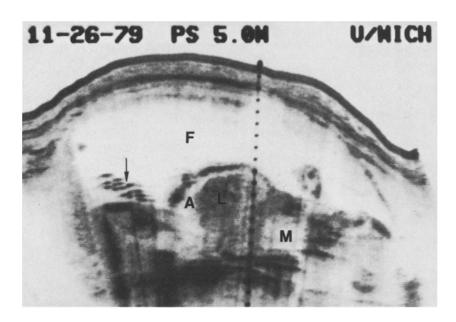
Longitudinal sonographic scan of gravid uterus at 29 weeks gestation. Note fetal ascites (A) and cystic mass (M) in the fetal chest. Marked hydramnios (F) is present. (L) indicates fetal liver. Arrow indicates umbilical cord
